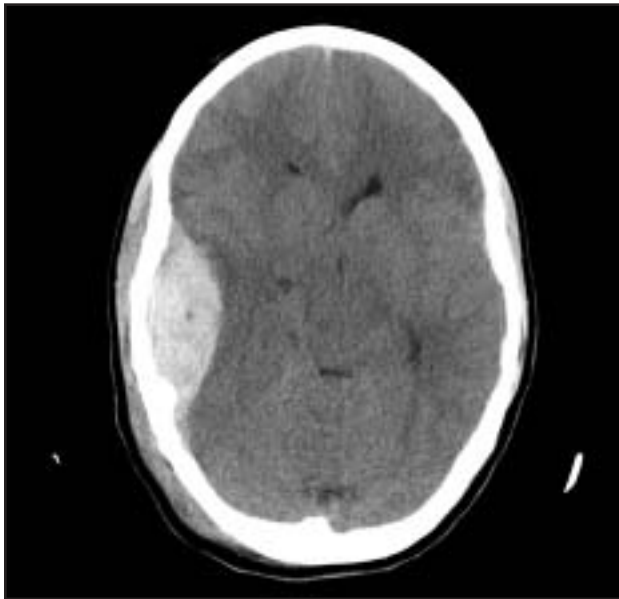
CT scan of head demonstrating a left temporal epidural hematoma.
